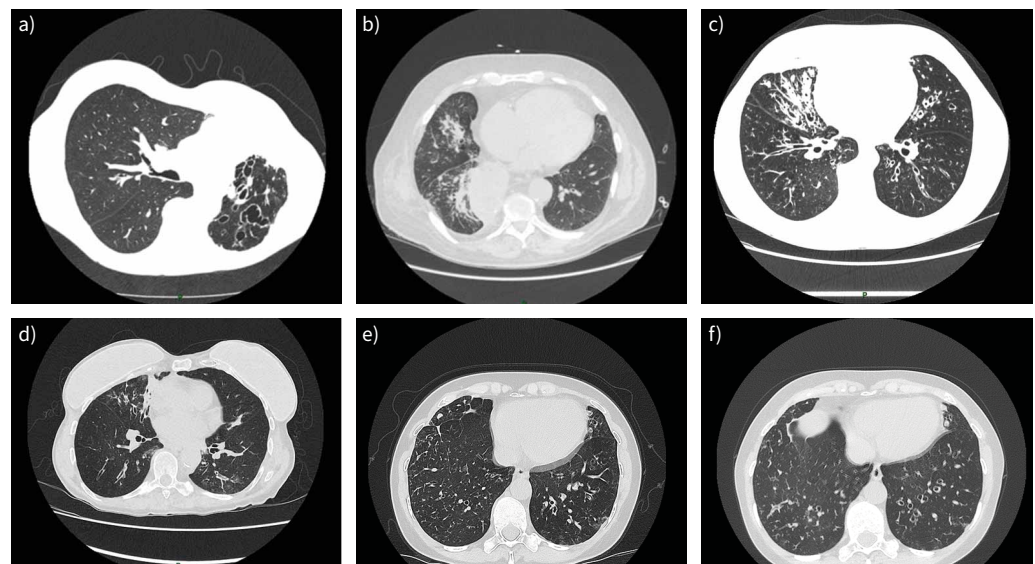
High-resolution computed tomography findings associated with different bronchiectasis aetiologies, and with treatment response. a) Localised bronchiectasis affecting the lingula and left lower lobe (with previous left lower lobectomy) due to severe childhood infection; b) bilateral lower-lobe bronchiectasis with mucus plugging, worse on the right with associated inflammatory nodules, in a patient with chronic aspiration due to previous oesophagectomy and gastric pull-up; c) middle-lobe varicose bronchiectasis with bronchial wall thickening and extensive mucus plugging due to primary ciliary dyskinesia; d) middle-lobe bronchiectasis with tree-in-bud nodularity due to *Mycobacterium avium* pulmonary disease; e) idiopathic bilateral lower lobe bronchiectasis with mucus plugging most marked in the left lower lobe due to *Pseudomonas aeruginosa* infection; f) improvement in appearance with reduced mucus plugging following nebulised colomycin to treat *P. aeruginosa*.
